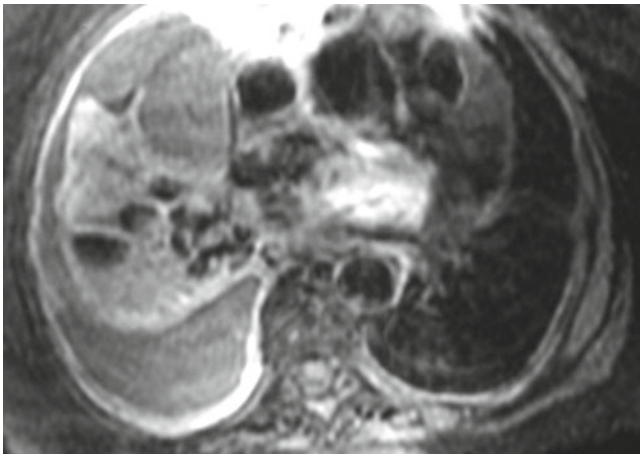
A right-sided empyema, seen on a fat-saturated T1-weighted sequence postgadolinium. It shows the pleural fluid to be of low T1 signal with marked associated pleural enhancement, seen as increased T1 signal
